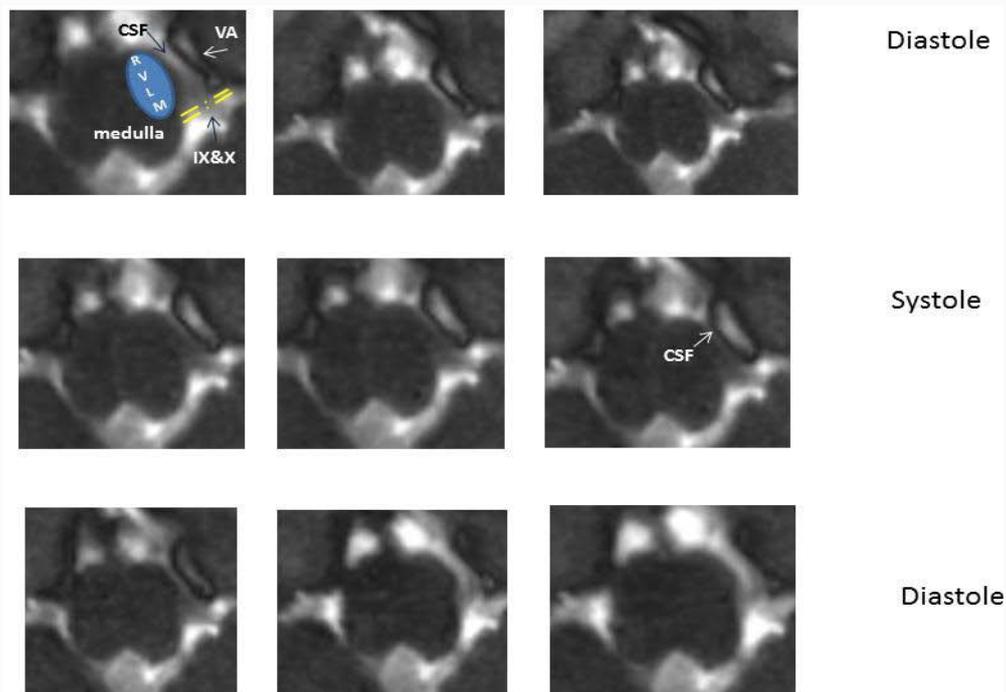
33-year-old moderate hypertensive patient. Real-time magnetic resonance imaging to visualize the neurovascular relationships in the posterior fossa. This is a first-time visualization of real-time MRI of dynamic pulsation of the vertebral arteries towards the Rostral Ventrolateral Medulla Oblongata (RVLM) during diastole (first and last row) and systole (middle row) contacting the presumed course of the fascicles of the glossopharyngeal and vagus nerves. Note that during diastole the luminal diameter of the left-sided Vertebral Artery (VA) is physiologically narrow and widened during the systolic phase and potentially pushing towards the medulla oblongata in the moderately hypertensive proband, where a very distinct narrow Cerebrospinal Fluid (CSF) corridor can still be determined between the artery and the brainstem (CSF: Cerebrospinal Fluid; RVLM: Rostral Ventrolateral Medulla Oblongata; VA: Vertebral Artery; IX: Glossopharyngeal Nerve; X: Vagus Nerve).
